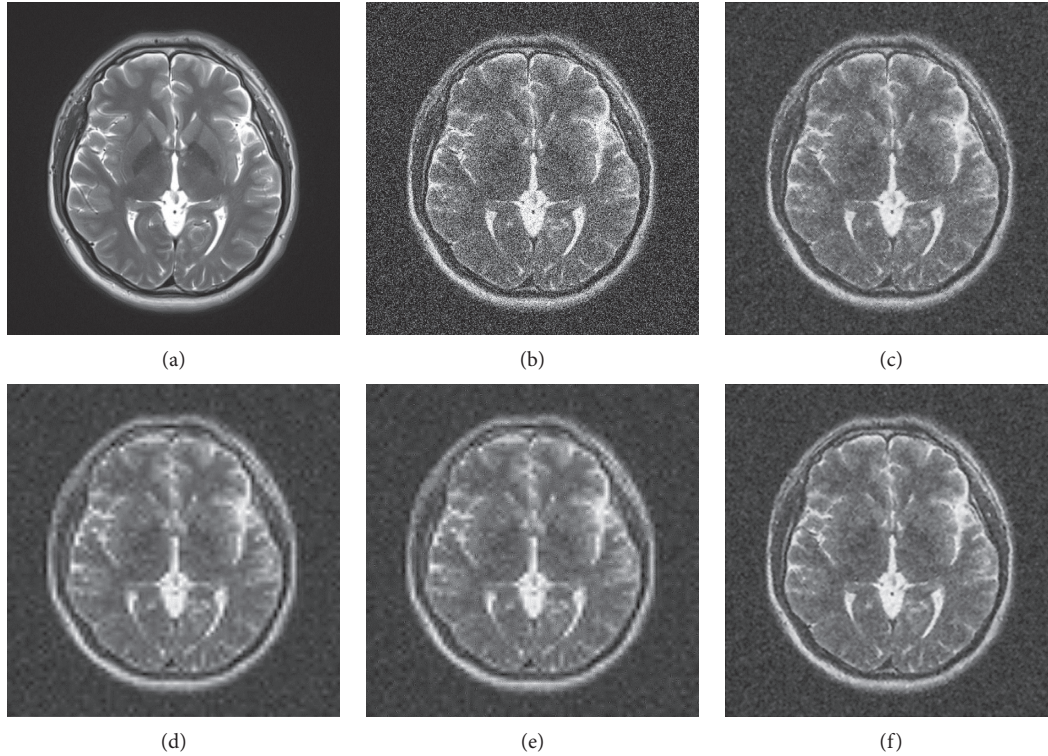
Subjective denoising results of MRI 1 in different ways. (a) Original image, (b) noisy image, (c) Wiener filter, (d) hard threshold, (e) soft threshold, and (f) proposed.
